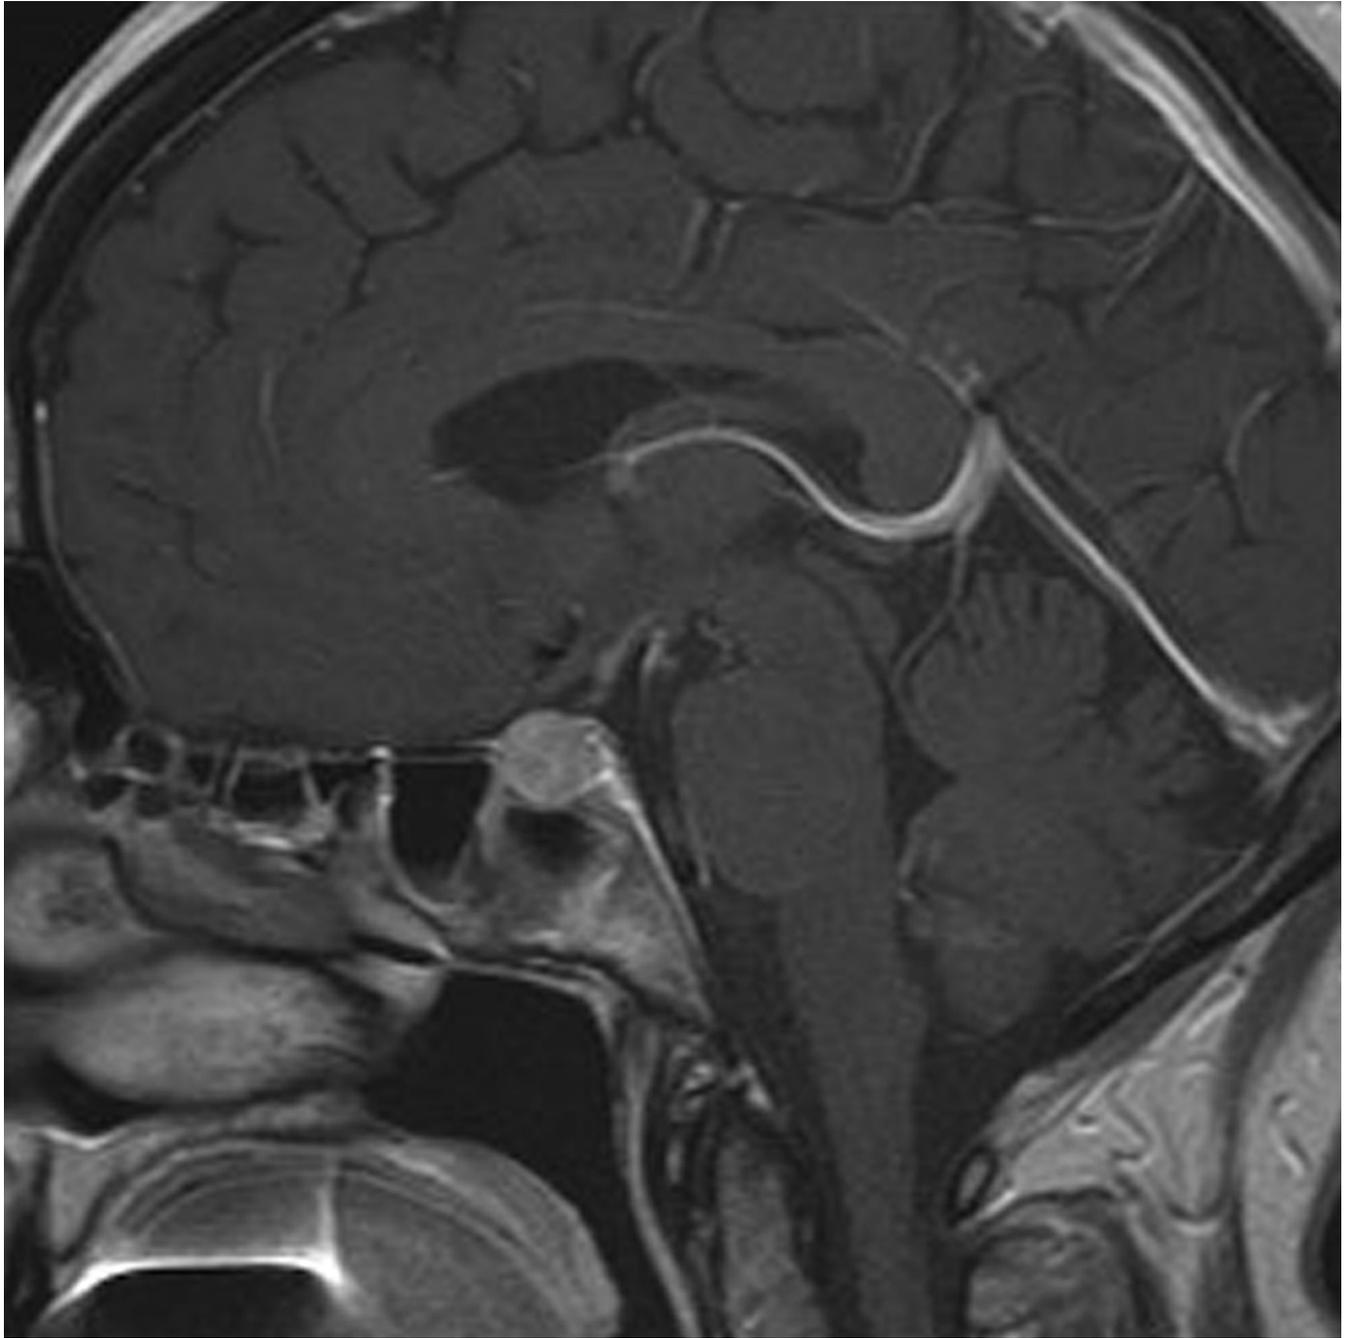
Ipilimumab-associated hypophysitis in a 56-year-old woman with metastatic melanoma. A, B. T1-weighted sagittal MR images of the brain prior to (A) and after (B) the administration of the intravenous contrast agent (gadobutrol) at 7 weeks since the initiation of ipilimumab therapy demonstrated a new marked enlargement of the pituitary gland with enhancement, indicating ipilimumab-associated hypophysitis. The study was negative for brain metastasis. The subsequent endocrinology work-up also revealed hypophysitis-related central hypothyroidism and secondary adrenal insufficiency. The patient was treated with oral
